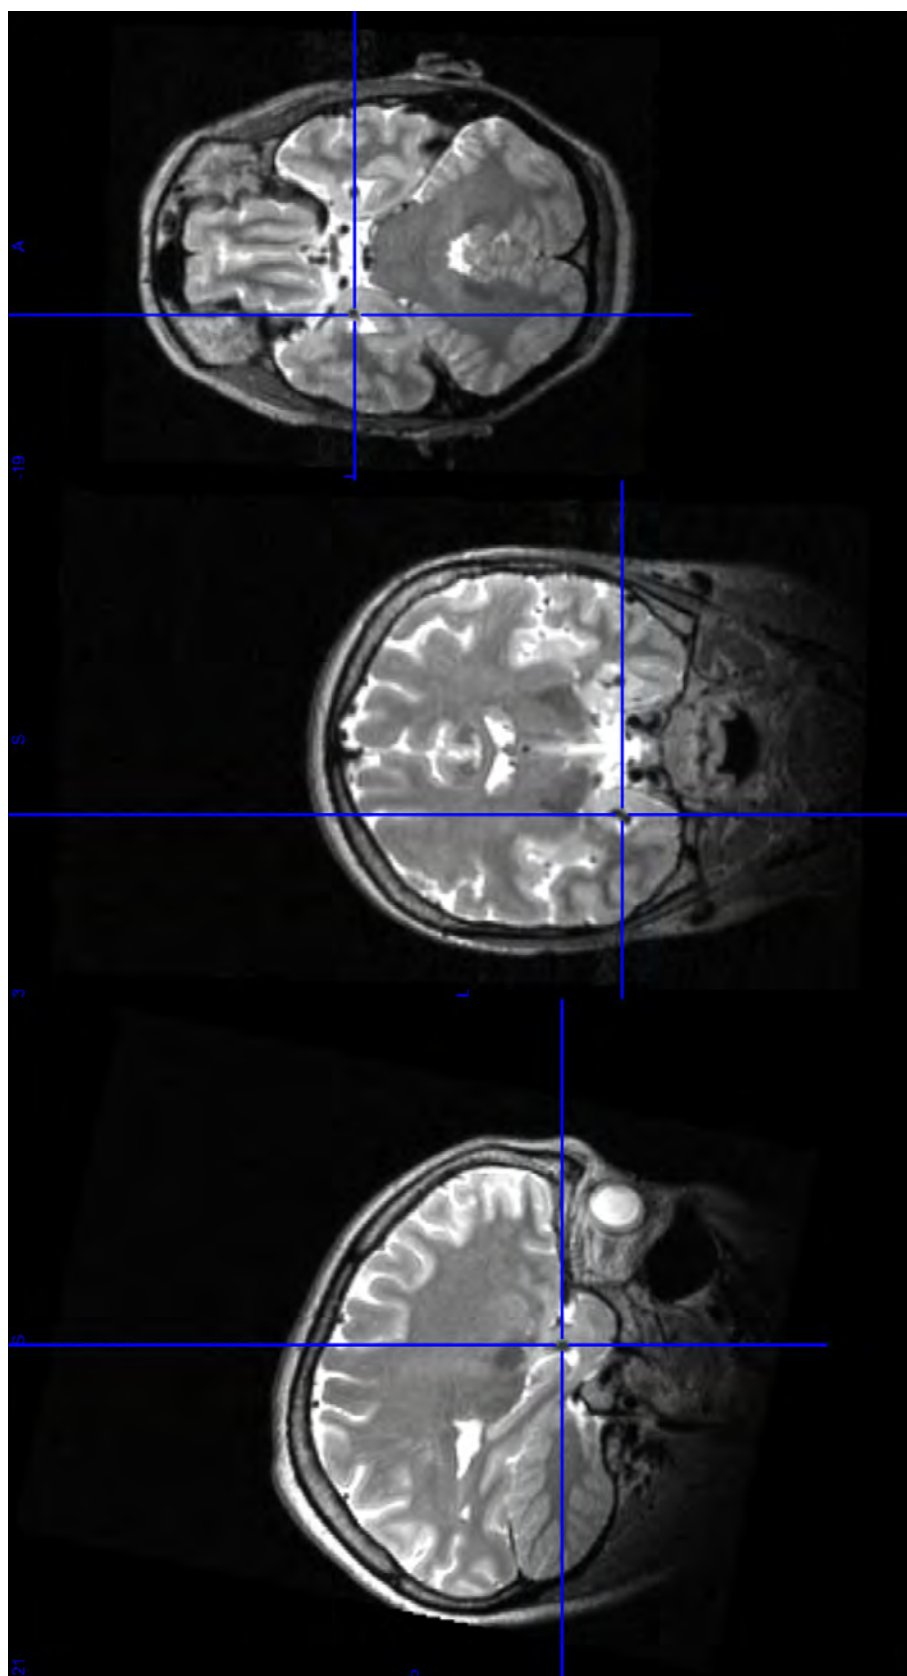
MRI scans for UWD patient no. 7.
